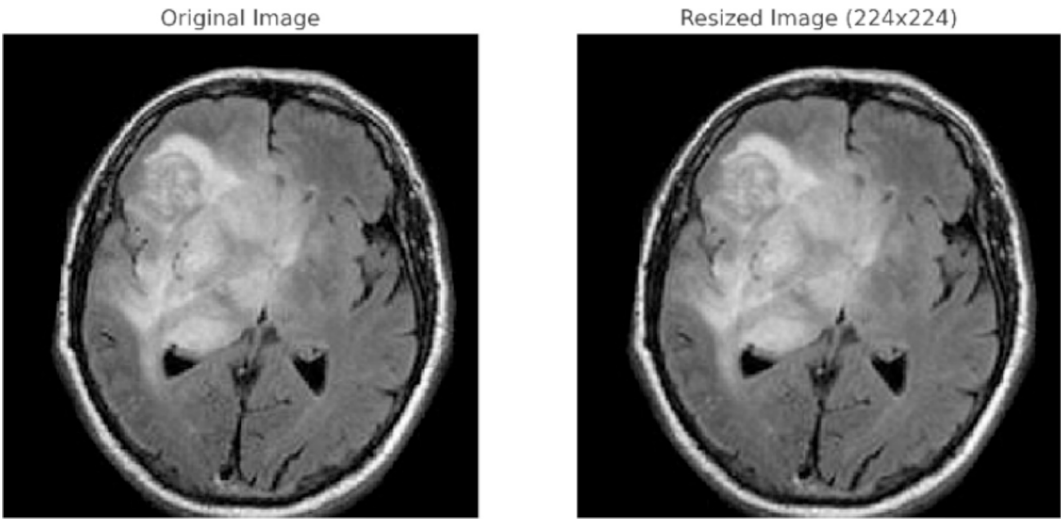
Example of an MRI image before and after resizing.
